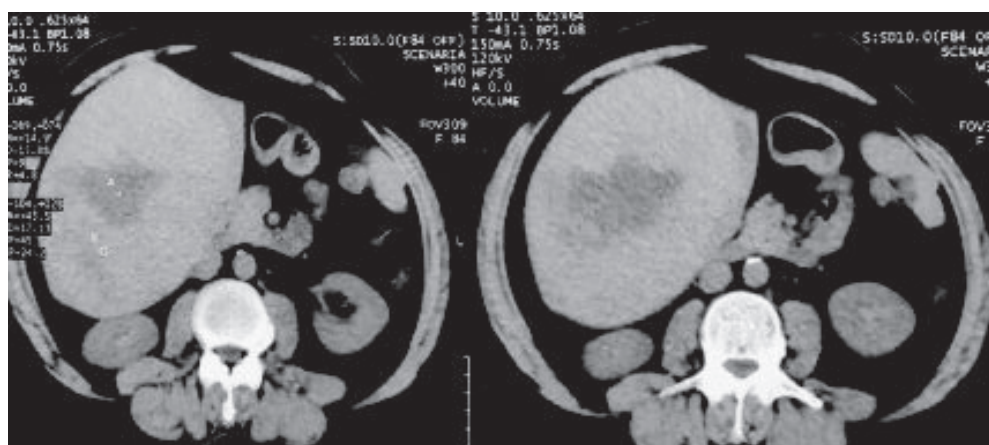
Axial non-contrast CT scan of the abdomen in a 52-year-old male with HCC showing an irregular hypo dense area in the right lobe of the liver (Case 19)
